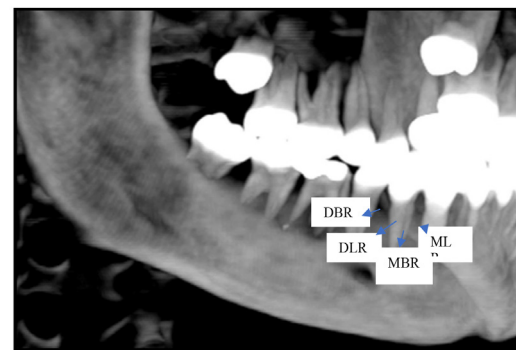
Spiral Computed Tomography image reconstructed by Dentascan software confirmed the presence of four rooted mandibular first molar
